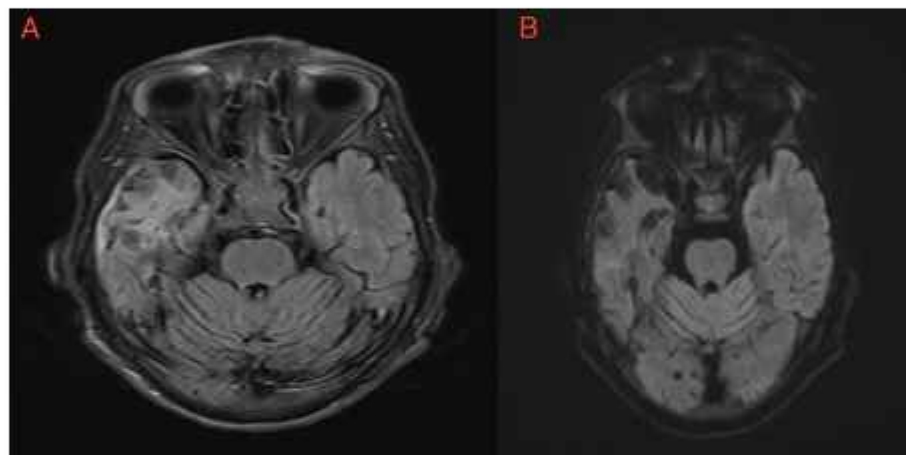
Heterogeneous high signal intensity in right temporal lobe in fluid attenuated inversion recovery (A) without restriction in diffusion-weighted MRI (B) showing remote necrotizing encephalitis.
